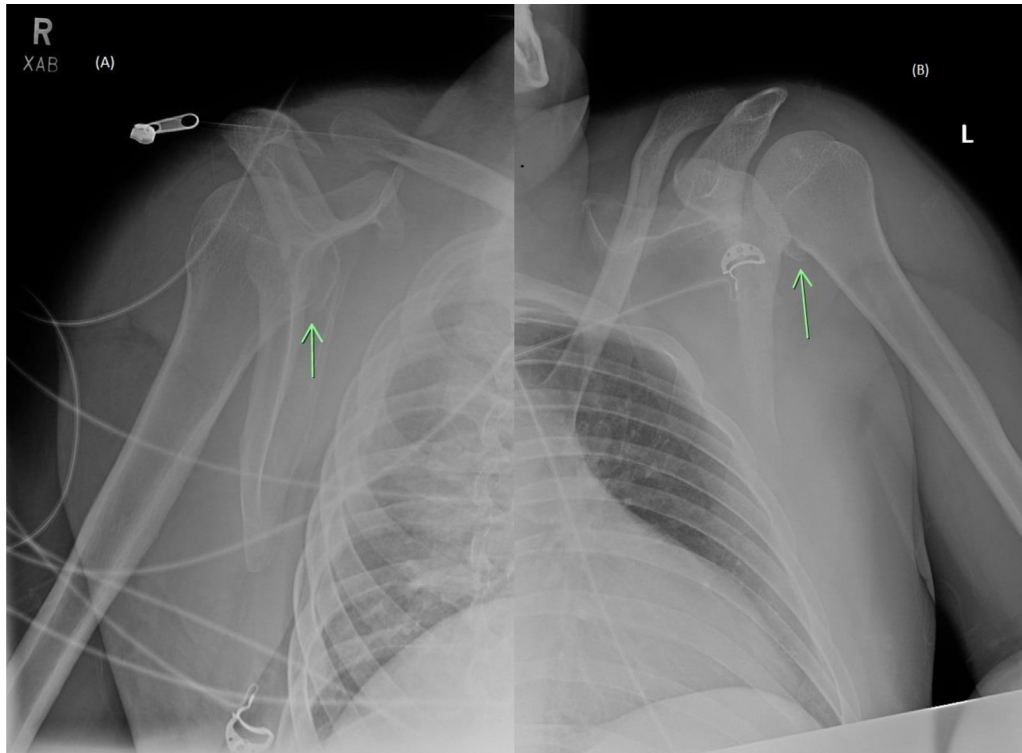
Scapular Y radiograph of right shoulder (A) and AP radiograph left shoulder (B) shoulder showing apparent fractures of the medial aspect of the humeral heads.
